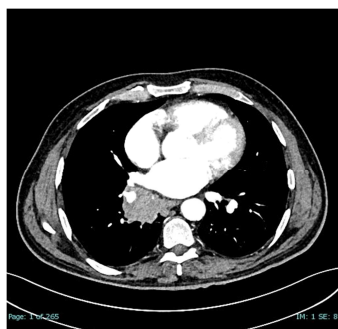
CT Scan before operation.
